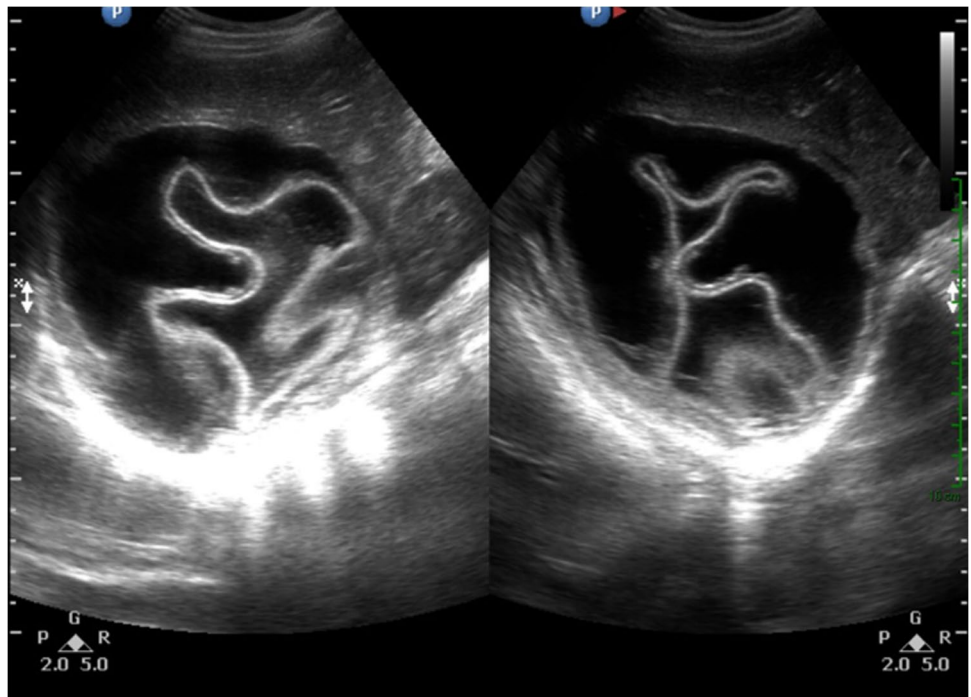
Hepatic hydatid disease in a 7-year-old girl from an endemic region. Transverse and longitudinal ultrasound images show a cyst with detached membranes (“water-lily sign”), classified as CE3a—group 2 of WHO classification, Gharbi II
